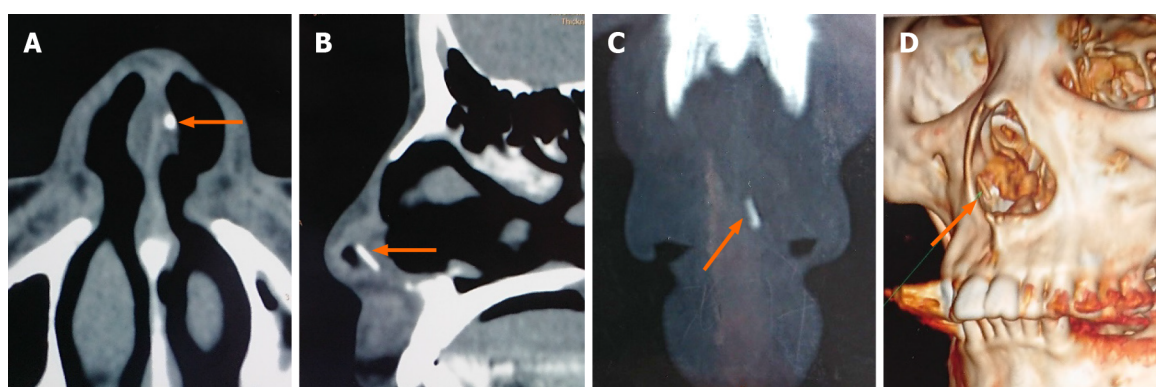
Computed tomography scan of the nasal sinuses before the third surgery. A: Axial plane; B: Sagittal plane; C: Coronal plane showing a pin-like foreign body with hyperdensity in the left side of the nasal septum; D: Three-dimensional reconstruction reconfirmed the position.
